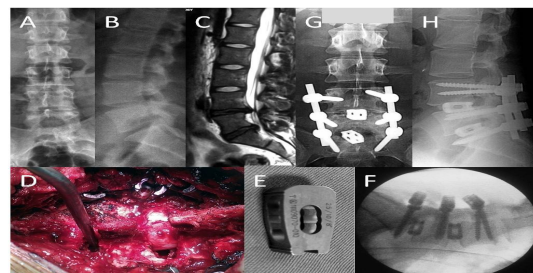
Transforaminal interbody fusion in a 43 years old male for DDD. A and B: AP and lateral radiographs of lumbosacral spine showing reduced L5-S1 disc space. C: MRI scan showing disc degeneration at L4-5 and L5-S1. D: Intraoperative picture showing decompression at L4-5 and sites of cage insertion at two levels. L5-S1 insertion site pointed by suction nozzle. Pedicle screw fixation is partially visible. E: Lumbar cage. F, G and H: Intra and post operative radiographs showing cages and pedicle screws in place. Disc height has been restored.
